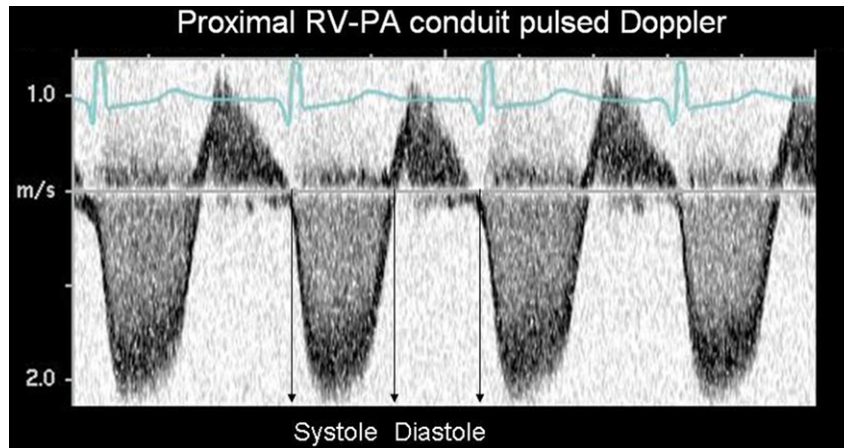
Systolic and diastolic time intervals obtained from flow signals in the mid-RVPAS with pulsed-wave Doppler echocardiography in an infant with HLHS after the Norwood procedure. The systolic duration is defined as the time from onset to cessation of antegrade flow (the flow signal below the baseline) and the diastolic duration as the time from cessation to onset of antegrade flow within the shunt (see arrows). PA, Pulmonary artery; RV, right ventricle.
